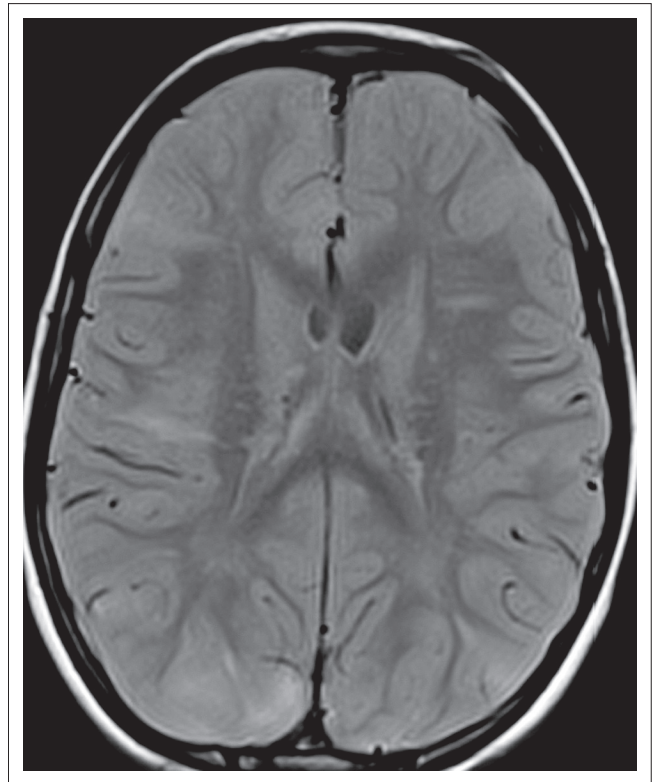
Axial FLAIR MR image.
